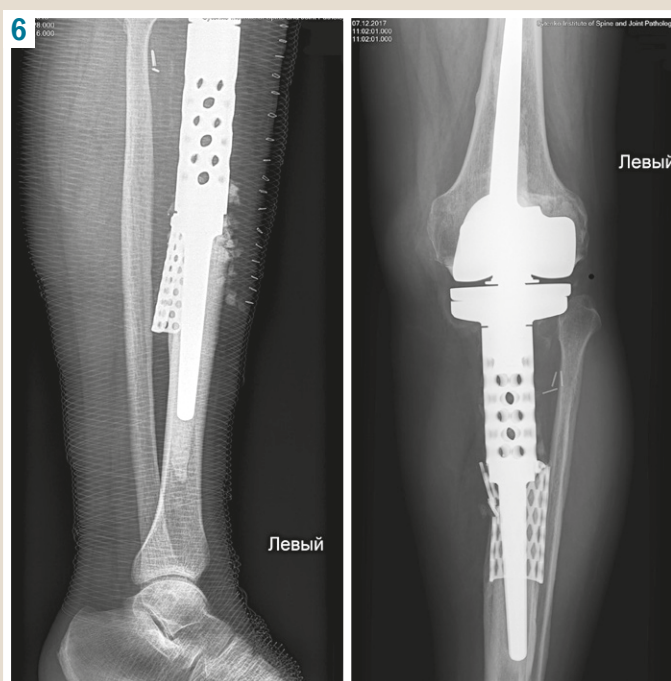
X-ray images: aseptic instability of the tibial stem endoprosthesis.
